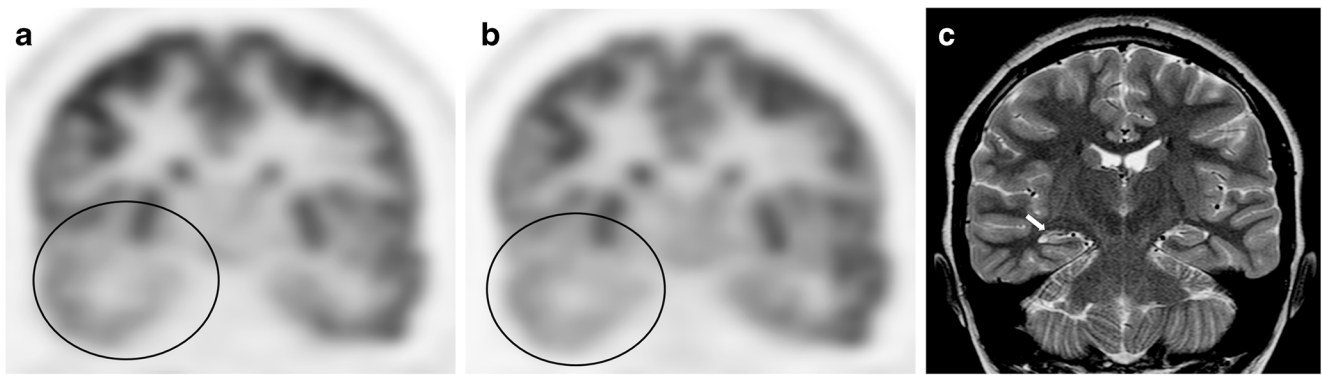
Positron emission tomography (PET)/CT- (a) and PET/MR- (b) acquired [F-18]2-fluoro-2-deoxyglucose (FDG) examinations in a 14-year-old boy demonstrate decreased tracer accumulation throughout the right temporal lobe (circles). Coronal fast spin echo T2-weighted image
